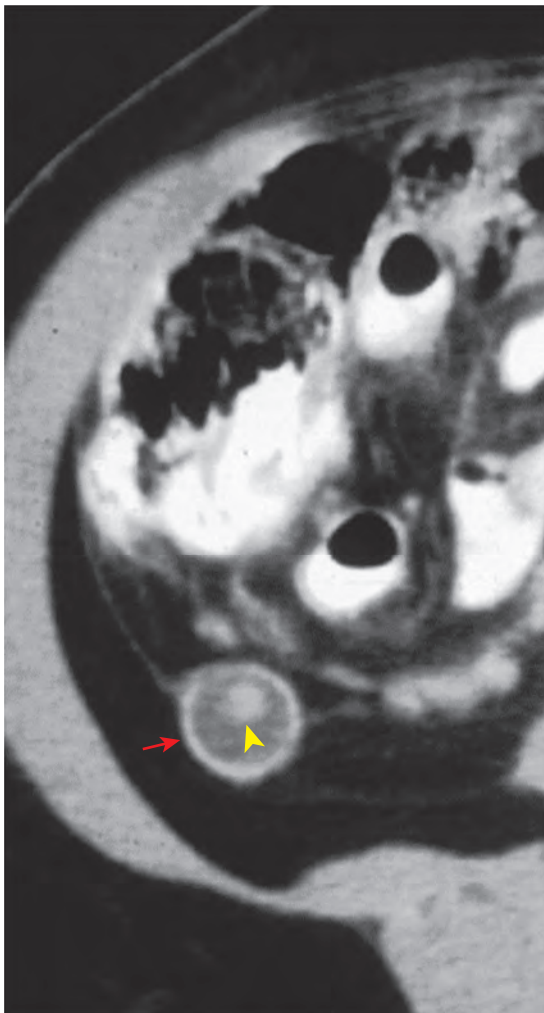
Acute appendicitis on enhanced CT. The distended appendix (arrow) is seen in cross section and demonstrates abnormal mural thickening and enhancement. In addition, an intraluminal appendicolith (arrowhead) is present.
